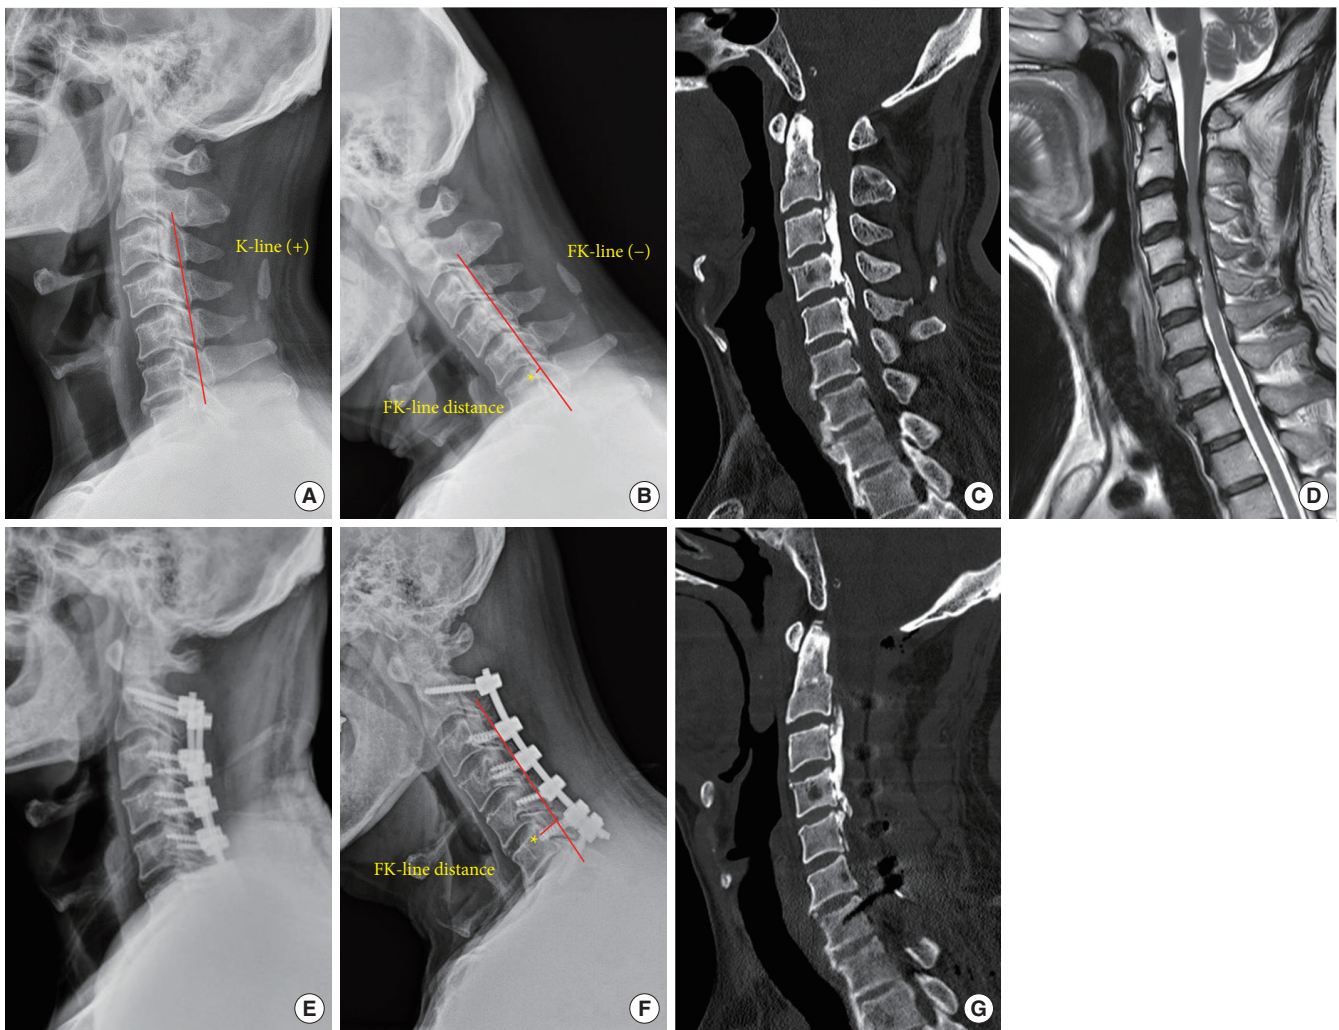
Representative case of LF in a patient with FK-line (-). A 64-year-old man with cervical OPLL involving C2–6 presented with bilateral numbness and weakness in all extremities. (A) Preoperative radiograph revealed a slightly kyphotic alignment and a positive K-line. (B) Flexion radiograph revealed a negative K-line (FK-line [-]) with an FK-line distance of 3.1 mm (asterisk). (C) Sagittal computed tomography (CT) demonstrated mixed-type OPLL from C2 to C6. (D) T2-weighted magnetic resonance imaging confirmed severe spinal cord compression. (E) Postoperative radiograph following LF at C2–7 showed improved alignment. (F) Postoperative flexion radiograph demonstrated correction of the kyphotic C2–7 angle and an increased FK-line distance of 13.0 mm (asterisk). (G) Postoperative CT confirmed effective decompression of the spinal canal. The JOA score improved from 12 to 16 (recovery rate: 80%) at 2-year follow-up. LF, laminectomy with fusion; FK-line, flexion K-line; OPLL, ossification of the posterior longitudinal ligament; JOA, Japanese Orthopaedic Association.
